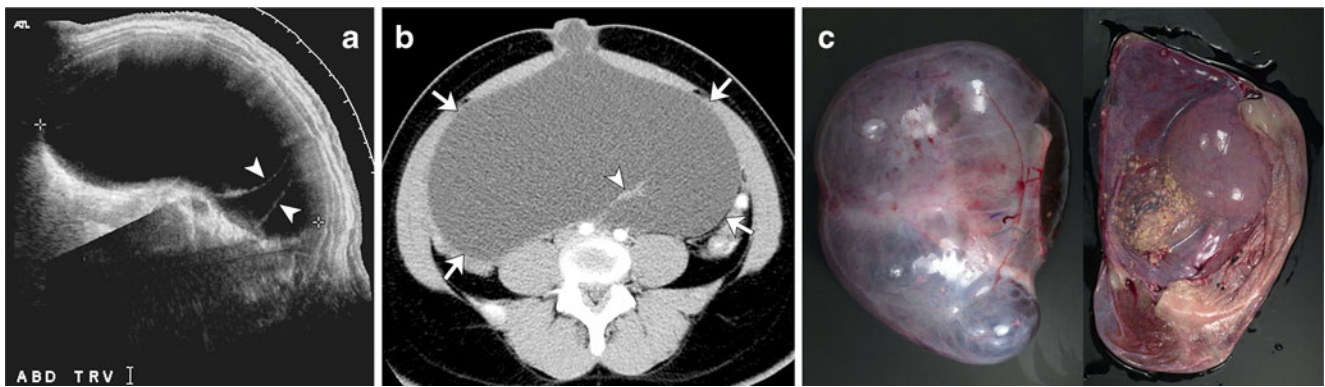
Juvenile granulosa cell tumor in a 14-year-old girl with increasing abdominal distention. a Transverse US scan through the abdomen shows a simple-appearing cystic lesion (*between calipers*) with a few thin septations (*arrowheads*). b Enhanced axial CT image shows a massive cystic mass with a simple appearance (*arrows*) and a few septations (*arrowhead*) that proved to be a juvenile granulosa cell
